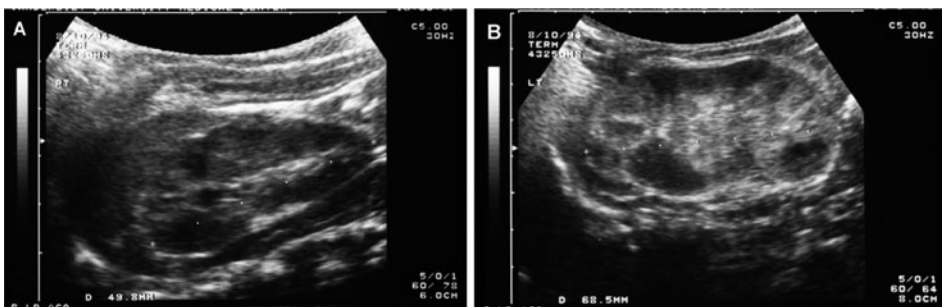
Renal venous thrombosis. (a) Renal ultrasound demonstrating normal right kidney. (b) Renal ultrasound demonstrating affected left kidney. The kidney is enlarged and swollen, with loss of normal corticomedullary differentiation.
